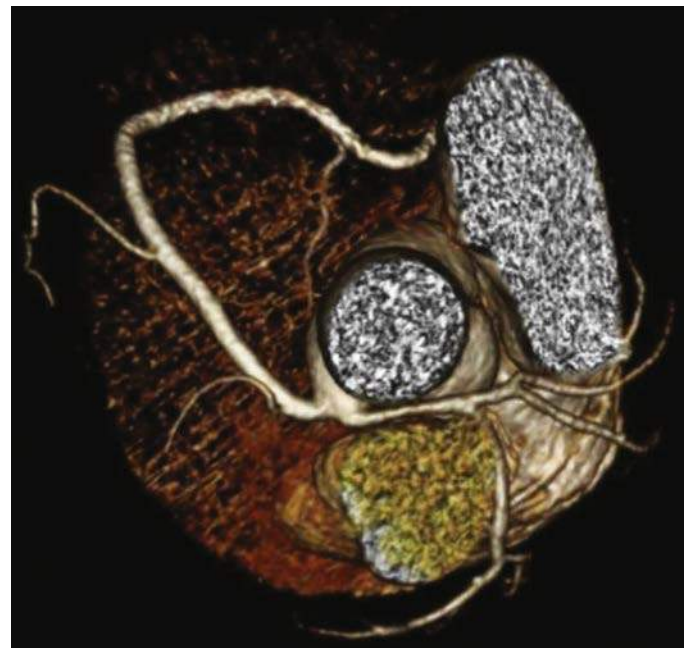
Three-dimensional-computed tomography reconstruction shows the aberrant origin of the left coronary artery from the right aortic sinus. There is also a common origin with the right coronary artery but no intramural course.
